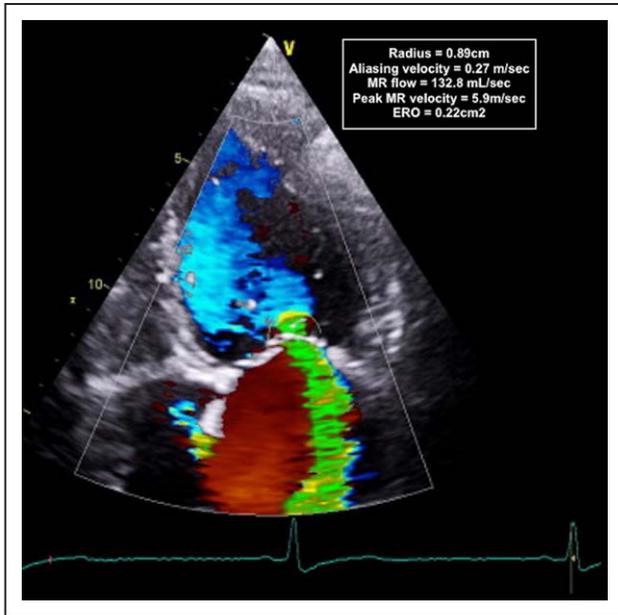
Transthoracic echocardiogram: moderate mitral regurgitation (MR). ERO indicates effective regurgitant orifice.
